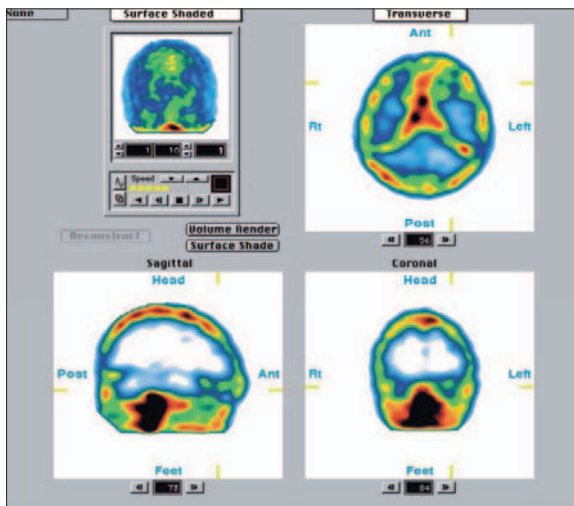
Single photon emission tomography (SPECT) of the facial skeleton after ^{99m}Tc-labeled erythrocytes. There is a visible focus of tracer accumulation in the upper part of the left orbital conus at the site of the suspected hemangioma.
